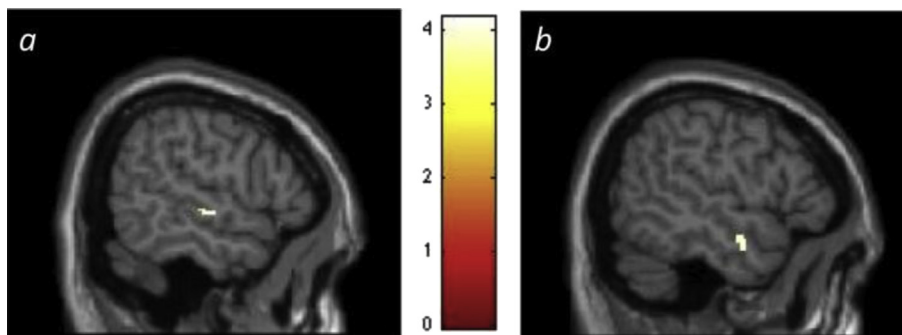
Open spaces activated the superior and middle temporal gyri in beauty judgments. *Notes.* (a) Superior temporal gyrus; (b) middle temporal gyrus. SPM rendered into standard stereotactic space and superimposed on to sagittal MRI in standard space. Bar represents magnitude of *T*-score.
